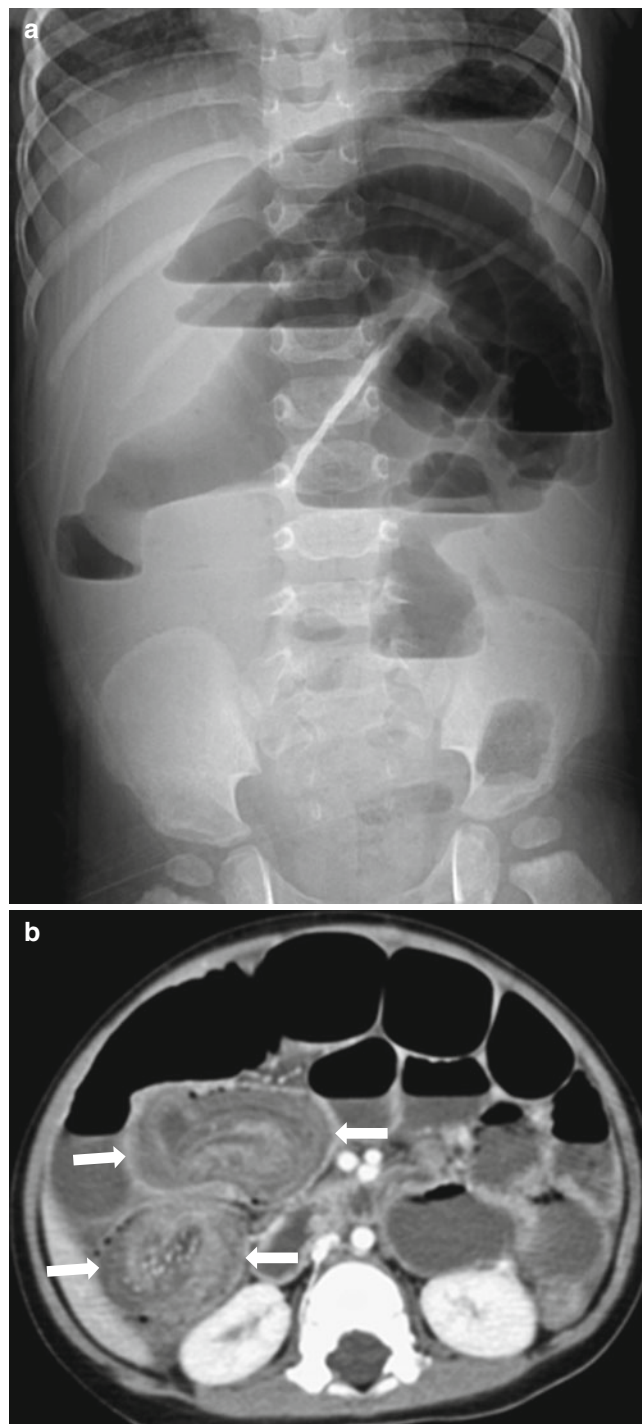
Intussusception in a 17-month-old boy presented with a 3-day history of decreased activity. (a) Upright abdominal radiograph reveals marked distension of small-bowel loops with multiple air-fluid levels suggesting mechanical ileus. Pneumoperitoneum is not seen. (b) CT demonstrates an intussusception (*arrows*) in which the invaginated multilayered bowels show somewhat decreased enhancement of walls with entrapped fluid. Air reduction was failed and an ileoileocolic-type intussusception was confirmed, followed by surgical resection of ileoileal component due to failure of manual reduction
